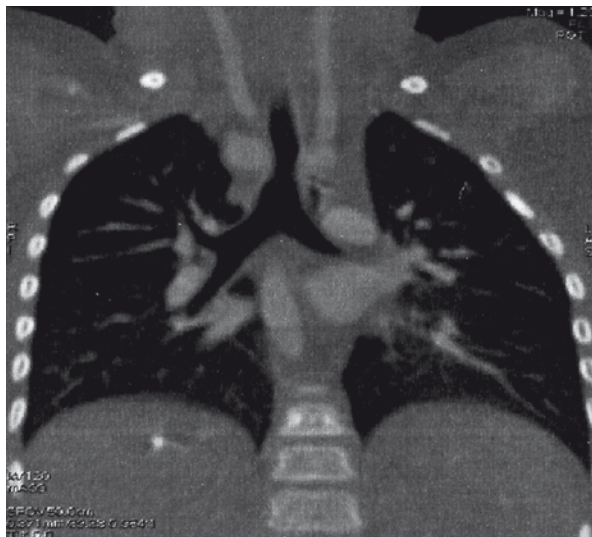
Repeated computed tomography 6 months after the operation– almost complete resolution of the tracheal compression
